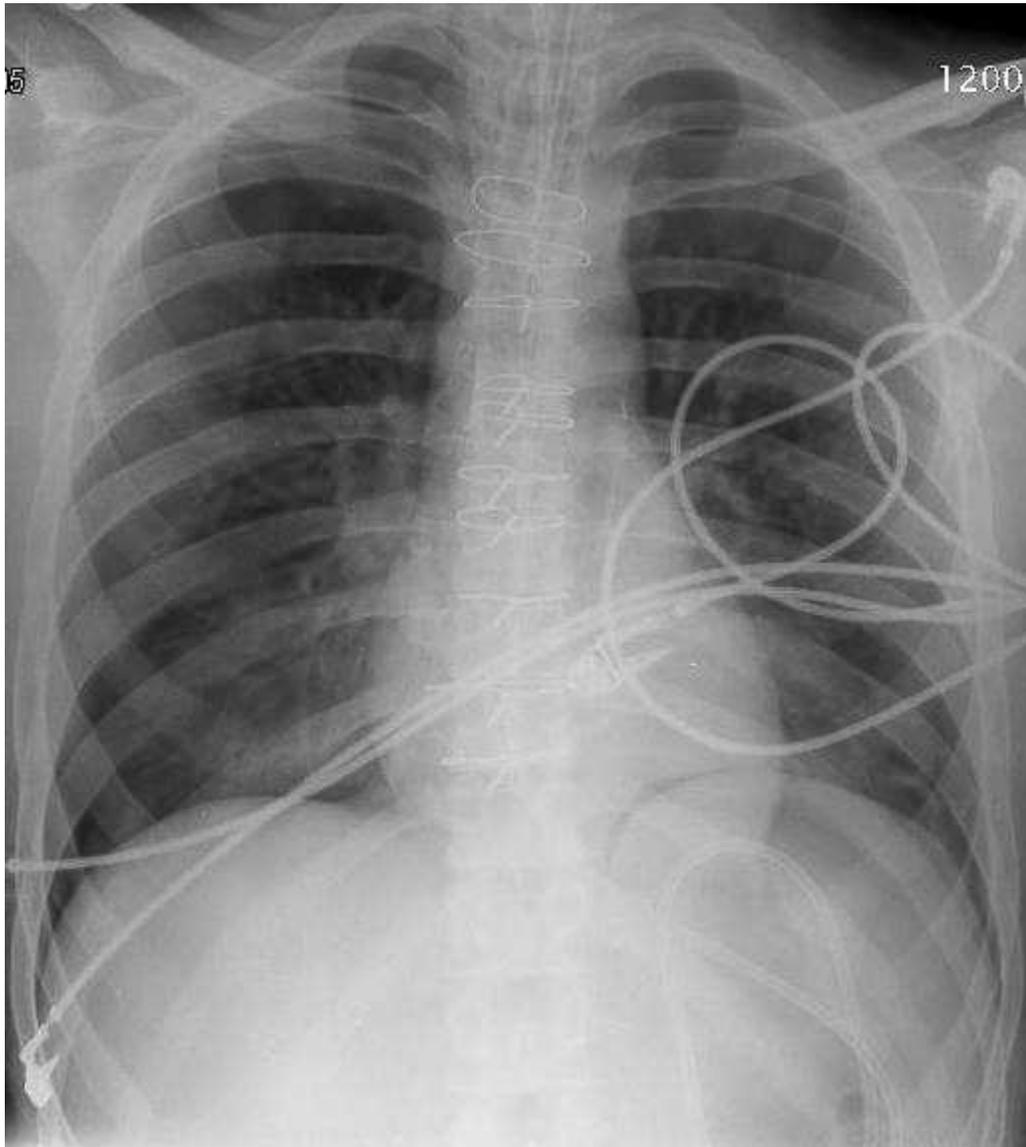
Chest x-ray showing bilateral pneumothoraces.
